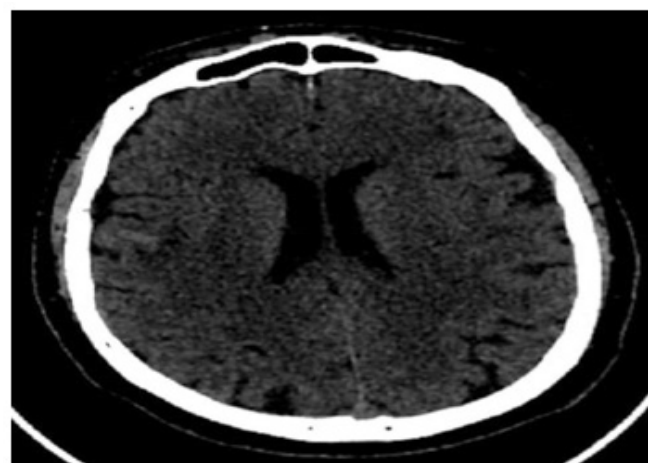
Non-contrast axial head CT examination reveals a linear, spontaneously hyperdense image located in the right precentral gyrus, extending from the cortical level to the deep white matter, with associated perilesional edema.
